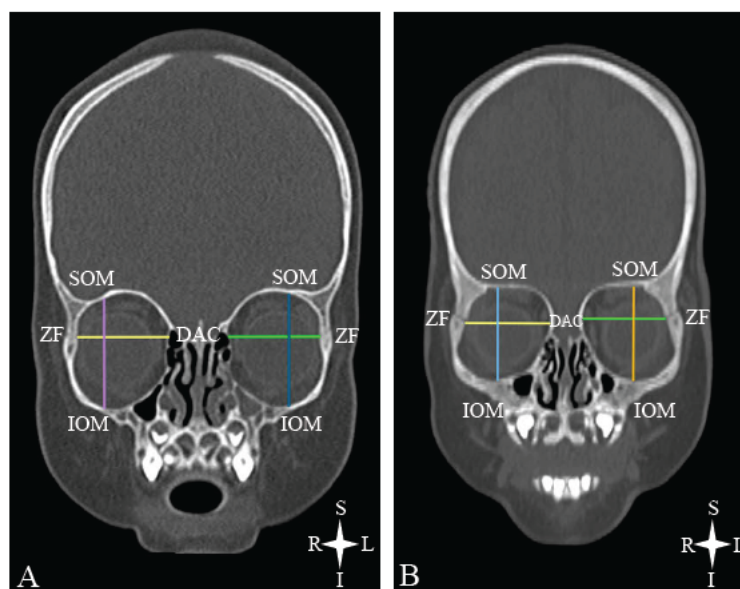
Orbital measurements on a coronal CT scan of a normal patient (A) and trigonocephaly patient (B) (height: IOM to SOM; width: ZF to DAC). Key: IOM – inferior orbital margin; SOM – superior orbital margin; ZF – zygomaticofrontal suture; DAC – dacryon
